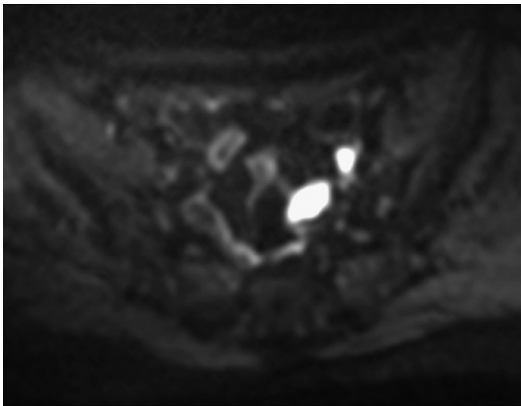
Left peritoneal implants. High SI on DWI related to restricted diffusion.
